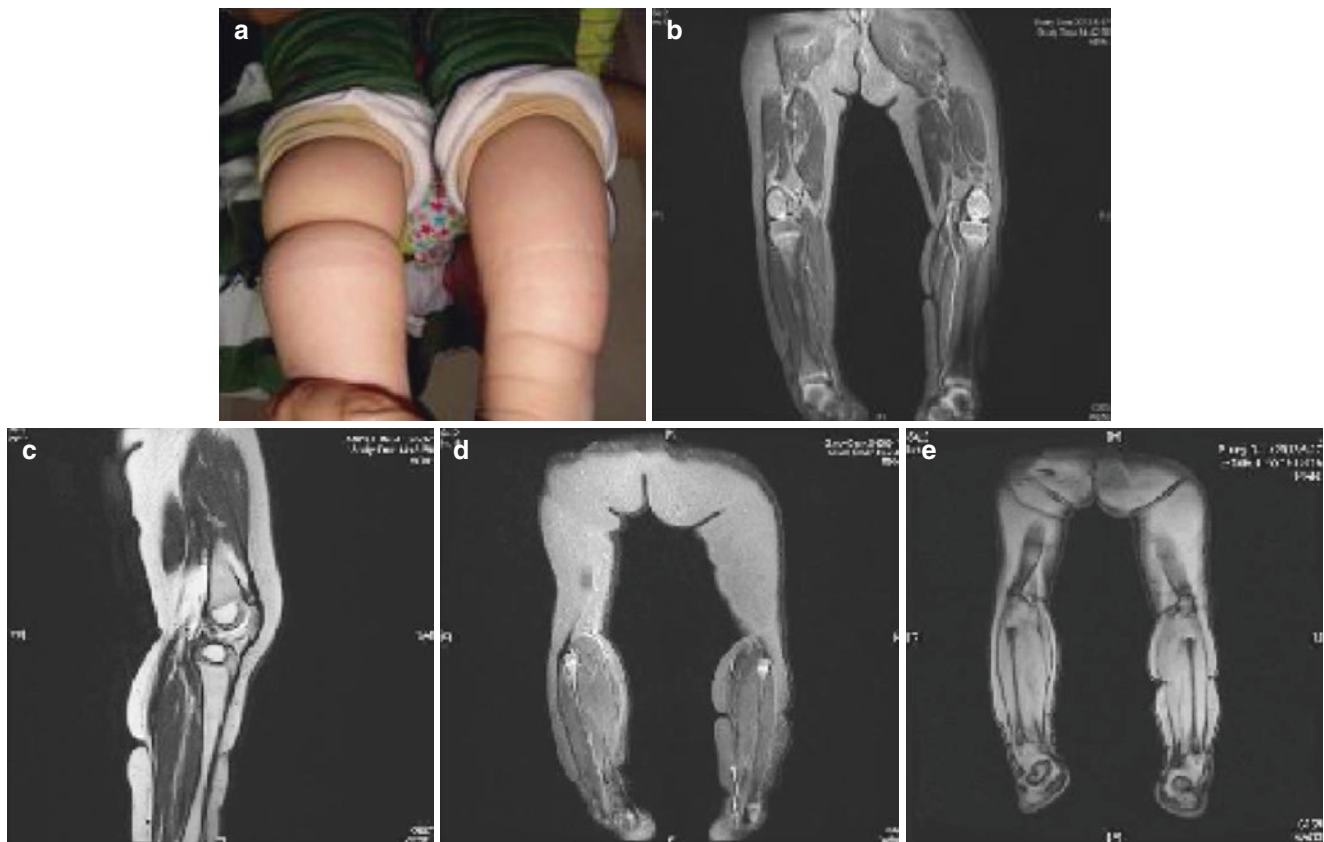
Left shank constriction ring is deep and present, and MRI displays that the deep vessels are not involved
